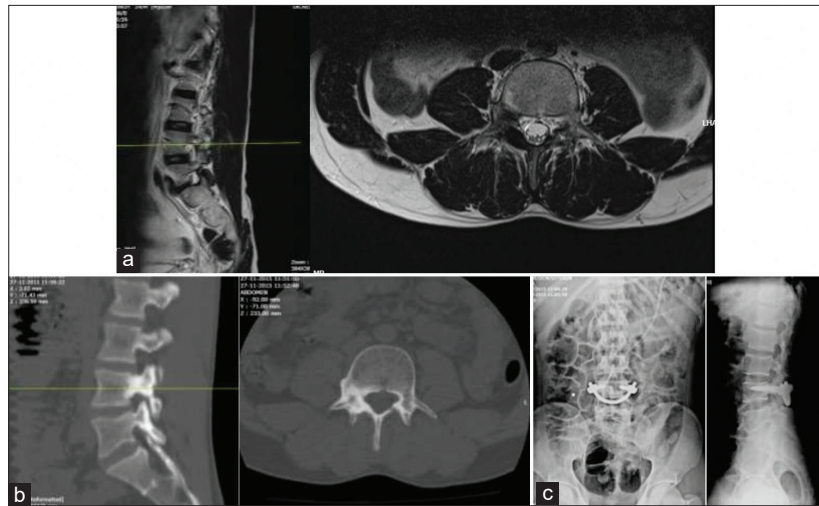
(a) Preoperative sagittal and axial T2-weighted MRI showing osteoid osteoma at L4 pedicle with pars lysis. (b) Sagittal and axial CT scan showing osteoid osteoma involving L4 pedicle with lysis of pars (c). (c) Postoperative X-ray showing bilateral pedicle screw fixation with the left pars bone grafting.
